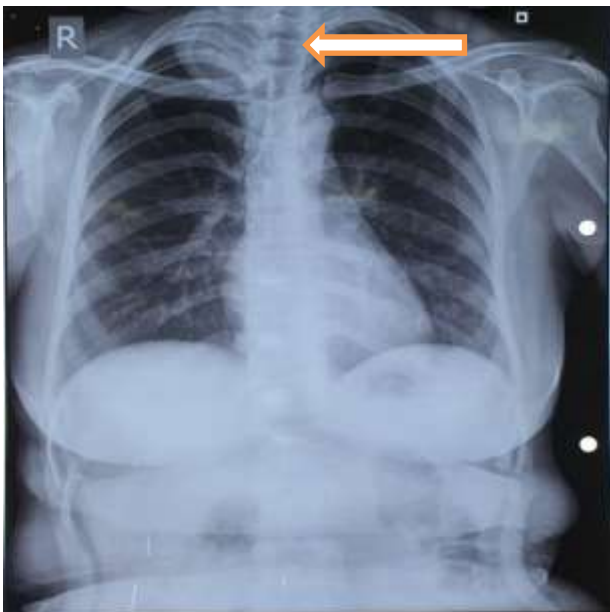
Chest X-ray PA view of the right apical opacity (arrow).
